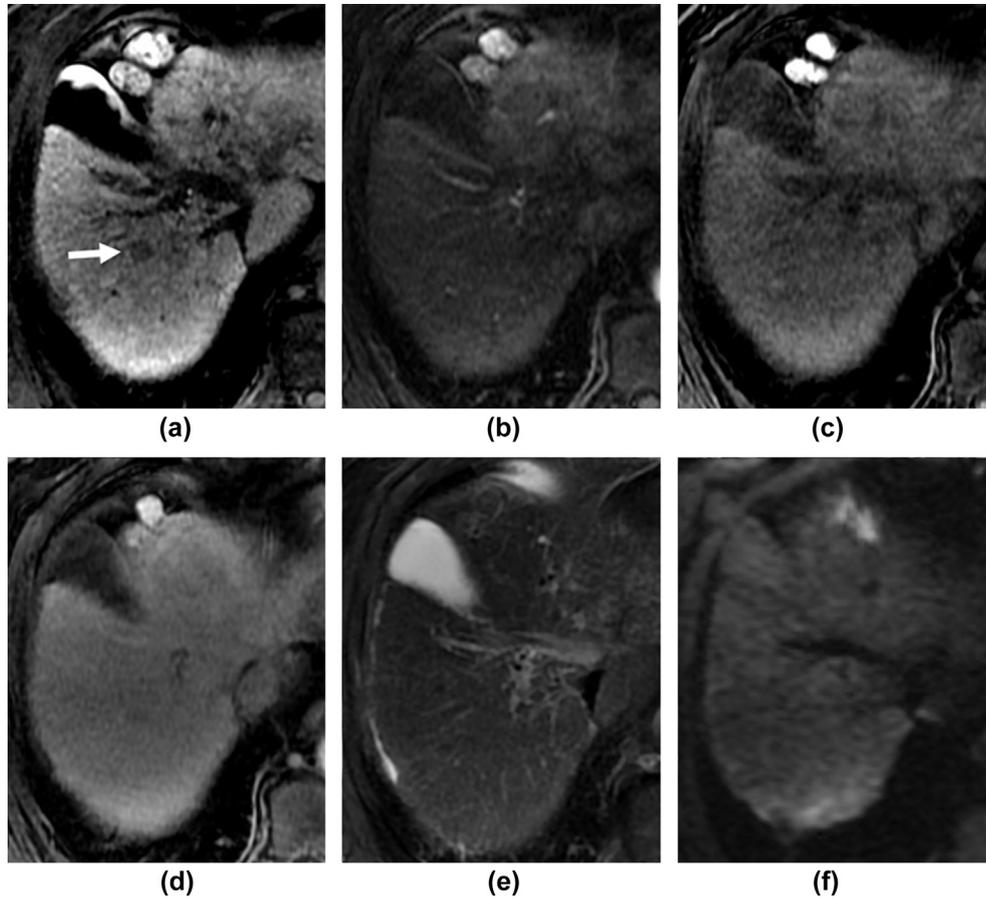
Imaging findings of a 66-year-old man with a HBP hypointense nodule without APHE. (a) HBP; (b) arterial phase; (c) precontrast image; (d) portal venous phase; (e) fat-suppression T2-weighted image; (f) diffusion-weighted image (b-value=1,000 s/mm²). (a) The HBP image shows a hypointense nodule of 8 mm in diameter at S7/8 (arrow). (b) The arterial phase image does not show hyperenhancement. (c–f) The nodule could not be detected in other phases.
